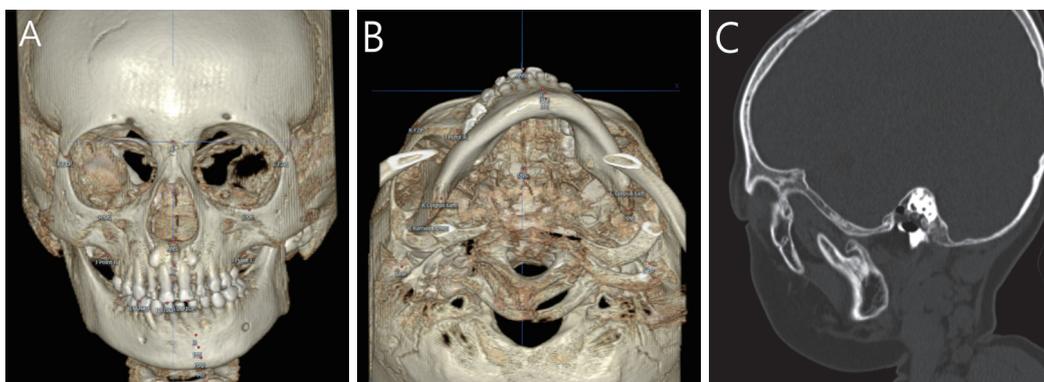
Initial CBCT view. (A) Mandibular displacement observed in frontal view. (B) Mandibular displacement observed in axial view. (C) Sagittal view from left side. Abnormal morphologies of condyle and ramus are presented.
